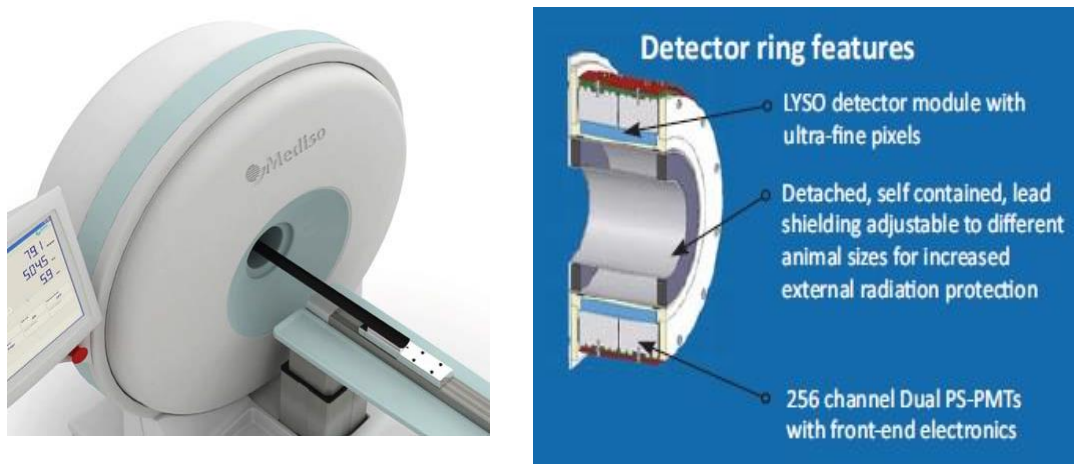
(Left) nanoScan PET/CT (Right) LYSO Detector ring system of PET (modified from nanoScan PET/CT user manual)
